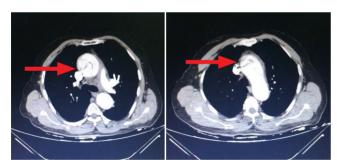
The manifestation of the patient that is compliant with Aortic dissection in his 3D dynamic thorax-abdomen CT
